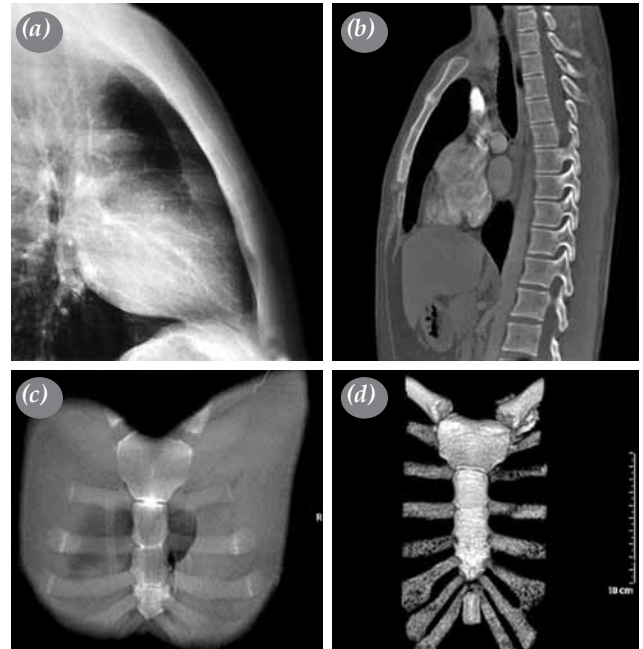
(a) Lateral chest radiograph of second patient demonstrating fissure lines on corpus sternum. (b) Sagittal, (c) coronal and (d) three-dimensional computed tomography images demonstrating transverse fissures dividing corpus sternum to parts.
